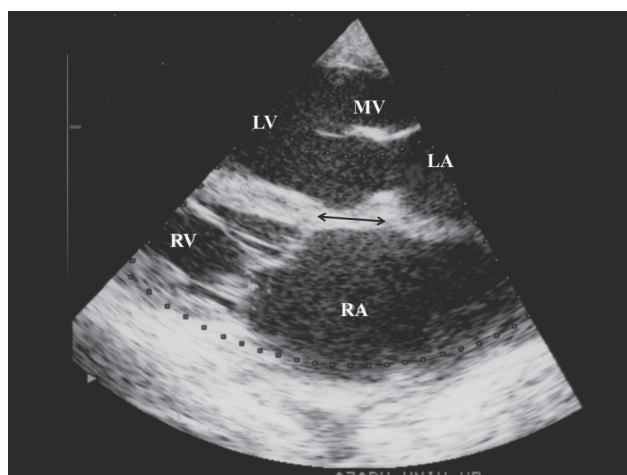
Ultrasonographic image of the heart in the calf with cervical ectopia cordis at 5 days of age. The left side of the figure shows the cortical apex that is directed cranially. The septal leaflet of the tricuspid valve is positioned toward the cardiac apex approximately 23 mm from the insertion of the anterior leaflet of the mitral valve (arrow). RV – right ventricle, RA – right atrium, LV – left ventricle, LA – left atrium, and MV – mitral valve.
